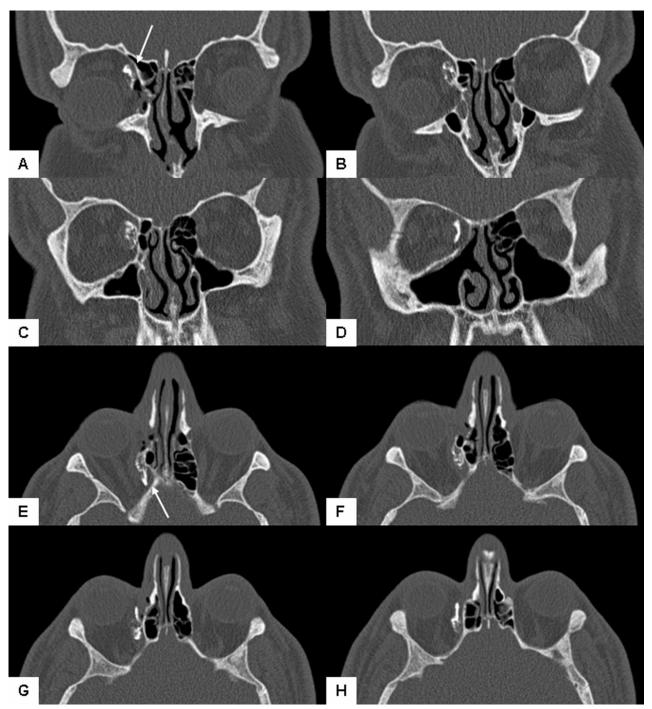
Coronal (A–D) and axial (E–H) CT views show the medial orbital mass.
